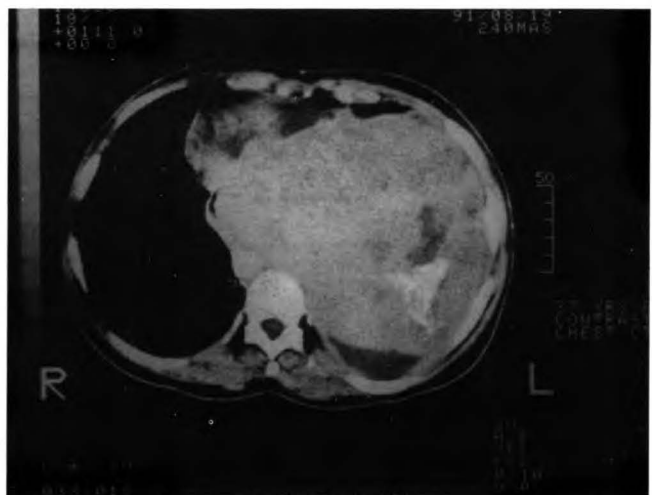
Radiograph of chest of case 5 showing the mass with calcification in left hemithorax.
